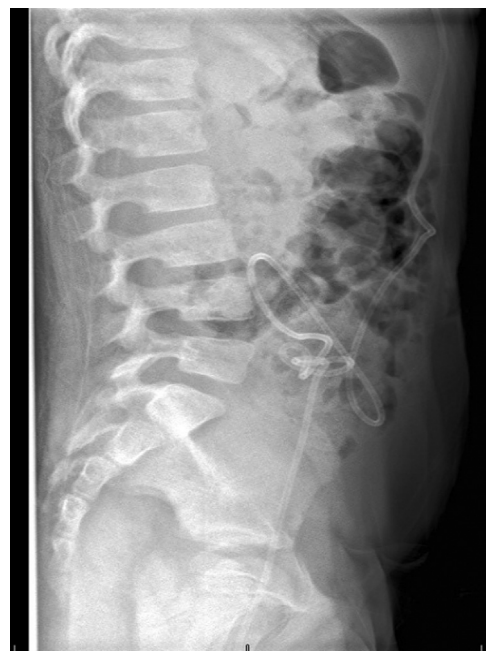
X-ray lateral decubitus position showing the loop in the right side of the abdomen. Image courtesy Lord et al¹⁵.
